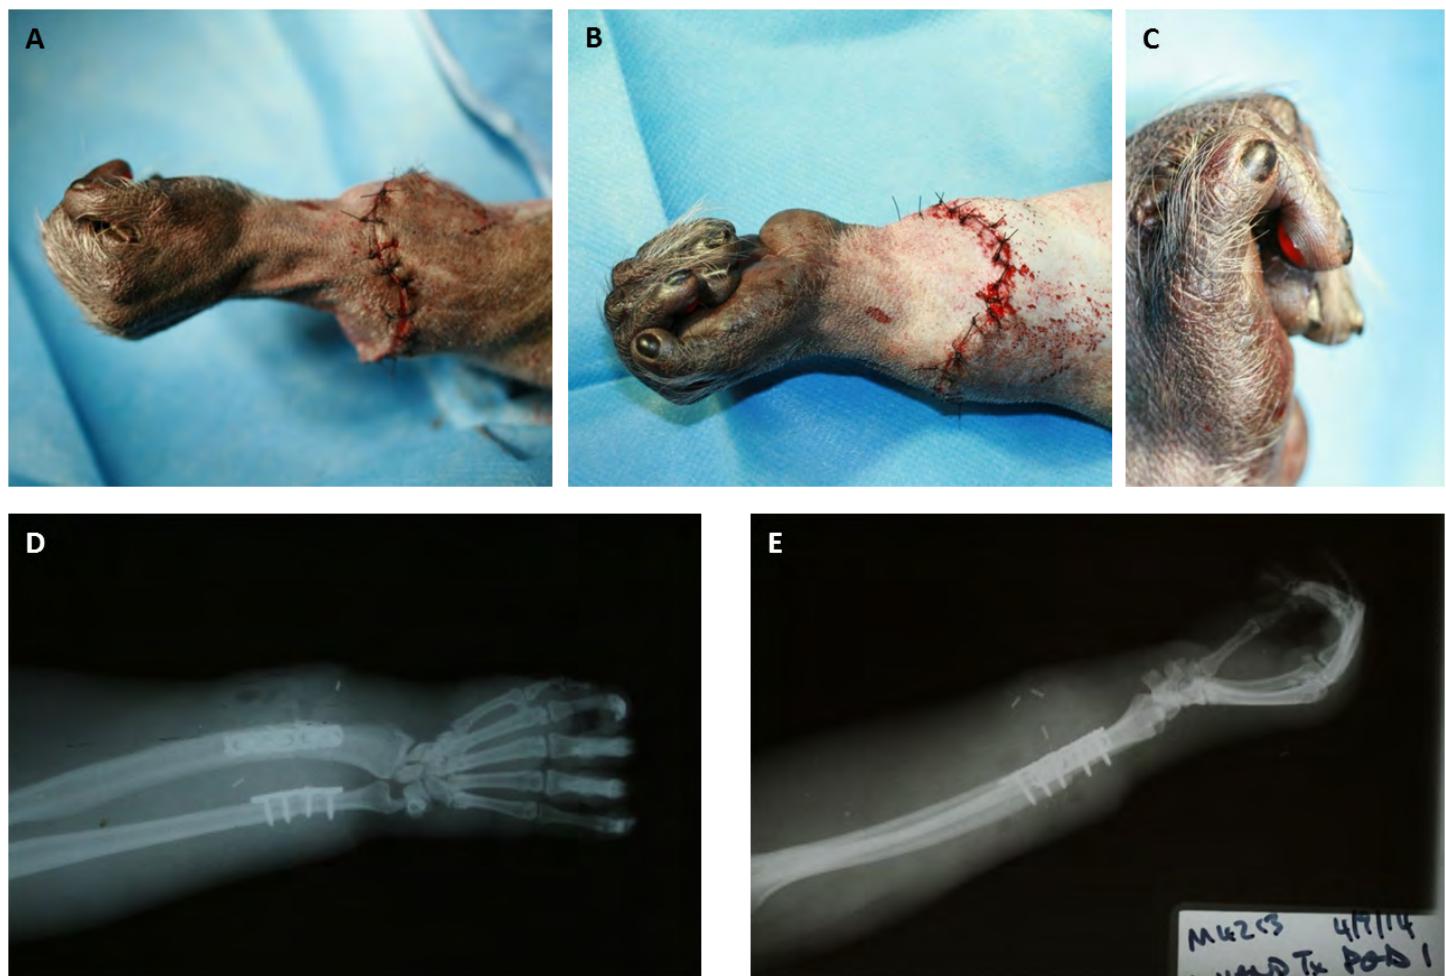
Immediate post-transplant appearance of transplanted hand (representative images recipient M4213). A) Radial view, B) Volar view, C) Finger bleeding perfusion test, D) AP radiograph, E) Lateral radiograph.
